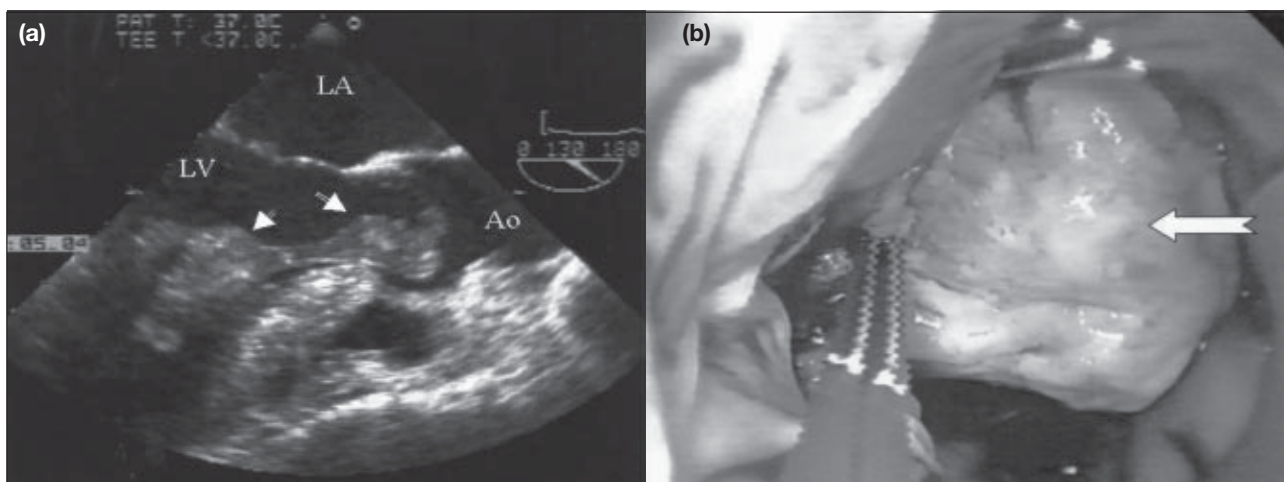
(a) Intra-operative transoesophageal echocardiogram showing a left ventricular mass (arrows) extending to the aorta during systole (Ao: aorta, LA: left atrium, and LV: left ventricle); (b) through a median sternotomy approach, the left ventricular mass (arrow) was noted arising between the two papillary muscle bases
